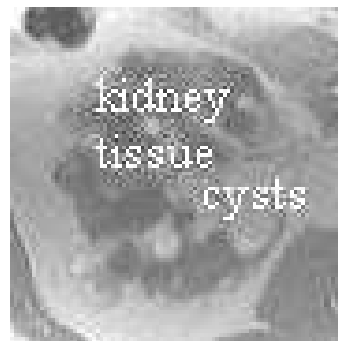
An MR image that is hard to segment because of strong contrast at undesired boundaries. Here, cysts with very different intensities than normal kidney tissues exist within the kidney.
